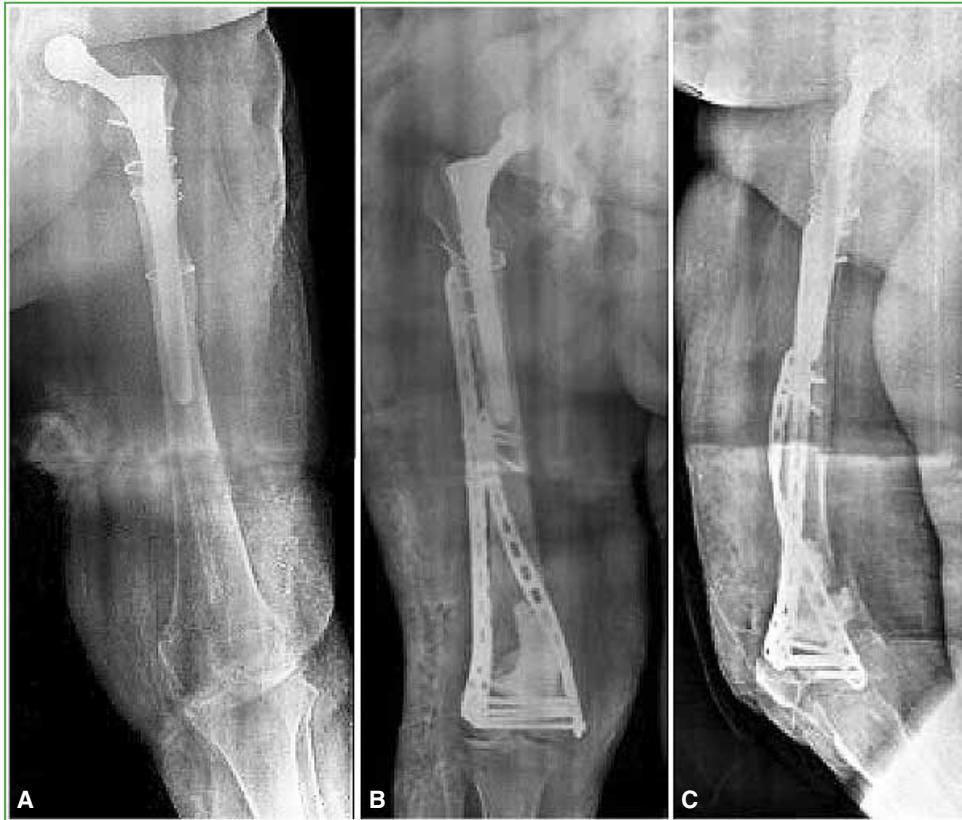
A. Anteroposterior panoramic radiograph of the femur in the preoperative period. A Vancouver type C periprosthetic hip fracture with compromise of the distal femur is observed. B and C. Anteroposterior and lateral radiographs of the femur in the postoperative period. Osteosynthesis with helical plate
